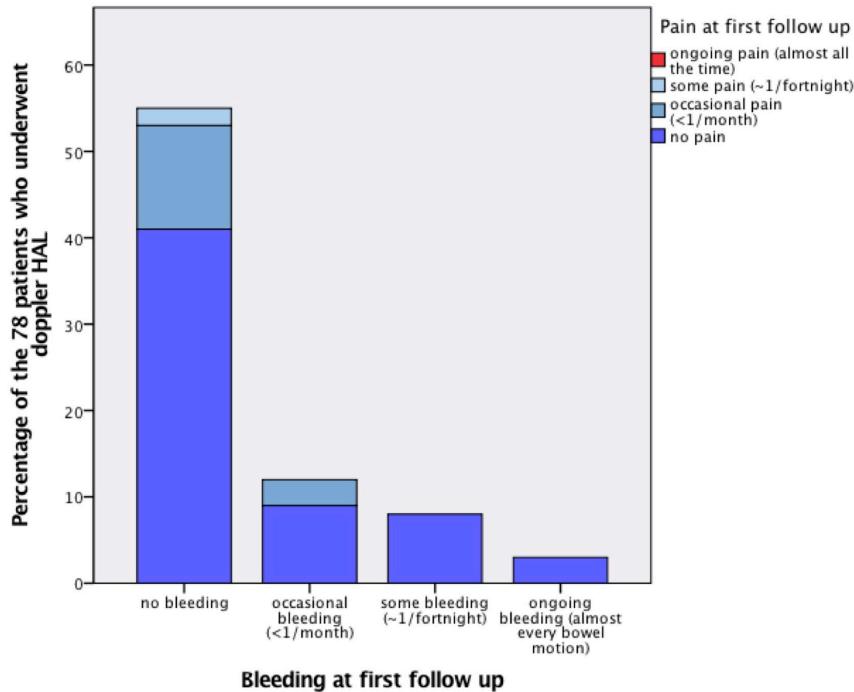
Combination of symptoms of pain and bleeding at first follow-up subsequent to Doppler HAL in case series of 78 patients (original figure)
